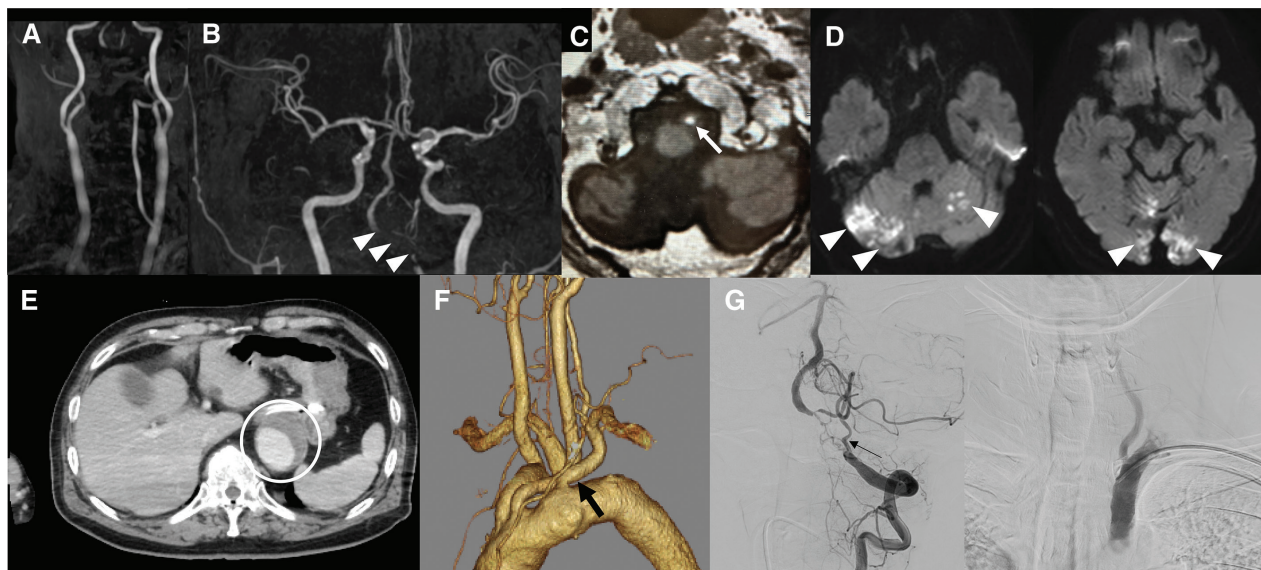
(A) MRA of the neck. The right vertebral artery was not visualized. (B) Intracranial MRA. Severe stenosis (white arrowheads) of the left vertebral artery was observed. (C) T1-weighted imaging. A high-intensity lesion was noted in the vertebral artery, suggesting the presence of thrombus (white arrow). (D) Diffusion-weighted image. Diffuse infarct areas were observed in the posterior circulation system (white arrowheads). (E) Abdominal contrast-enhanced CT. An
